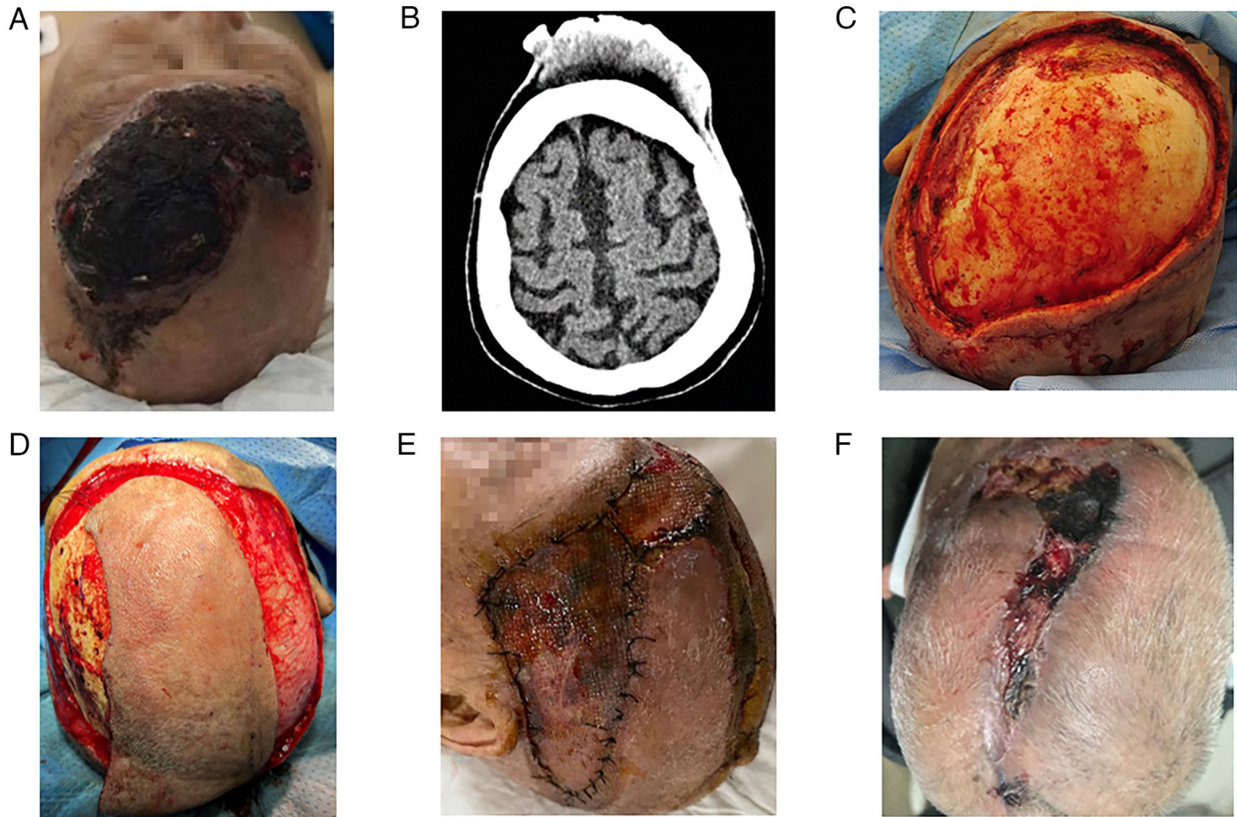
Clinical information of the patient. (A) On physical examination an irregularly shaped mass measuring ~14.0x7.0 cm was identified, most of the surface of the mass was broken and bleeding. (B) Cranial computed tomography demonstrated an irregular soft tissue mass of uneven density in the frontal region. (C) Following curative-intent surgery. (D) Intraoperative image of the first postoperative flap grafting and skin grafting. (E) Seven days after the second postoperative flap grafting and skin grafting. (F) Twenty days after surgery, some of the tissue at the edges of the surgical area had become necrotic.
